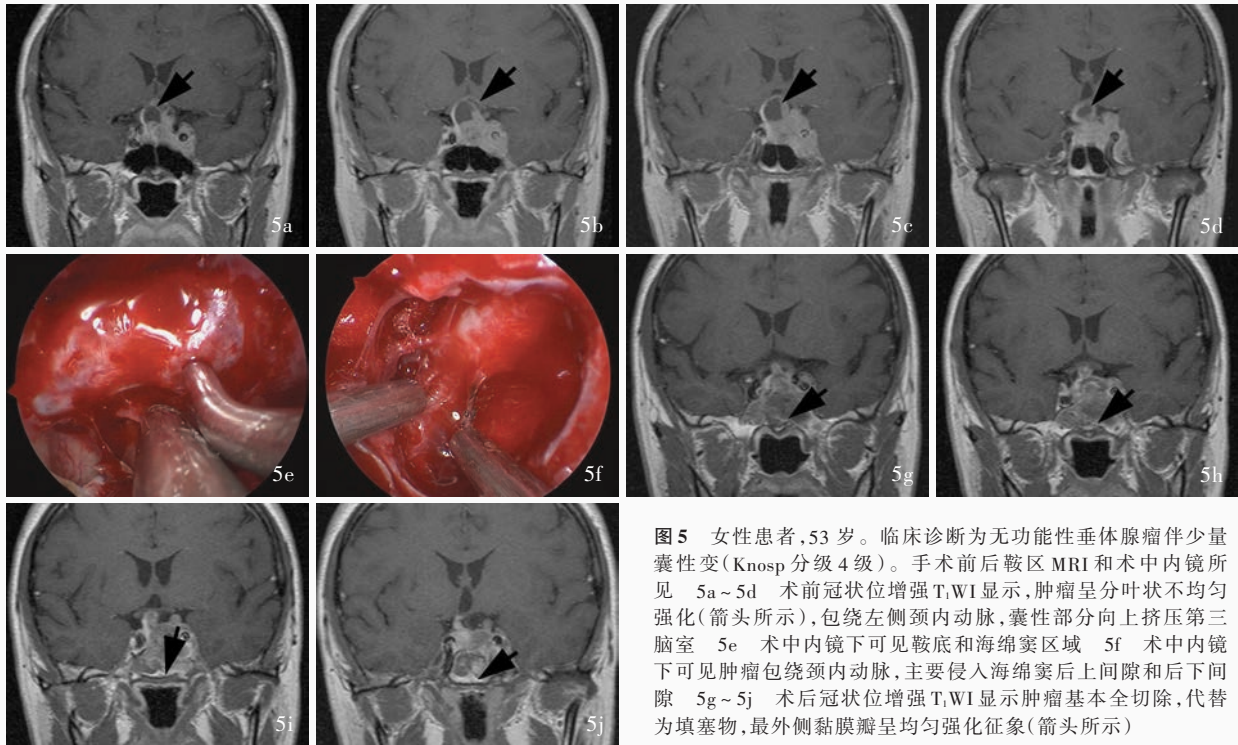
女性患者, 53 岁。临床诊断为无功能性垂体腺瘤伴少量囊性变(Knosp 分级 4 级)。手术前后鞍区 MRI 和术中内镜所见 5a~5d 术前冠状位增强 T₁WI 显示, 肿瘤呈分叶状不均匀强化(箭头所示), 包绕左侧颈内动脉, 囊性部分向上挤压第三脑室 5e 术中内镜下可见鞍底和海绵窦区域 5f 术中内镜下可见肿瘤包绕颈内动脉, 主要侵入海绵窦后上间隙和后下间隙 5g~5j 术后冠状位增强 T₁WI 显示肿瘤基本全切除, 代替为填充物, 最外侧黏膜瓣呈均匀强化征象(箭头所示)
